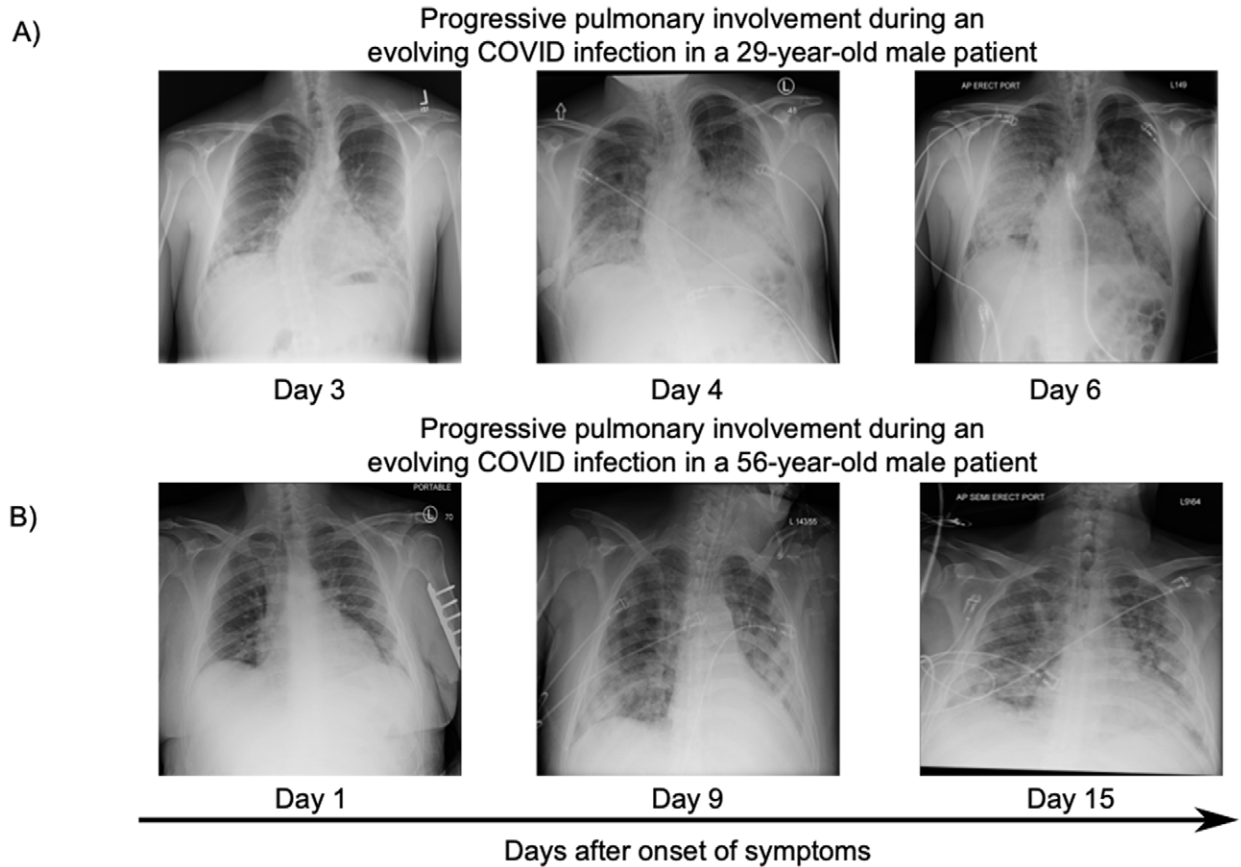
Representative serial chest X-ray imaging of COVID-19 infected patients. (a) 29-year-old man with rapid respiratory deterioration after symptom onset showing progression from lower lung predominant interstitial and airspace opacities on day 3 to diffuse involvement with extensive airspace disease on days 4 and 6. (b) 56-year-old-man with COVID-19, presenting initially with normal CXR, which then progressed to lower lung predominant interstitial and airspace opacities at day 9, which mildly worsened by day 15.
